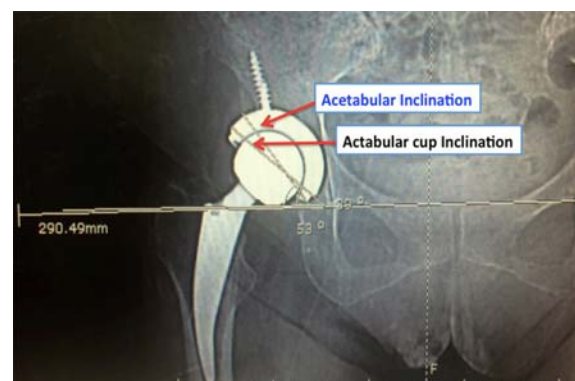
Measurement of the difference in inclination between the bony acetabulum and the acetabular cup from a CT scan of both hips.
